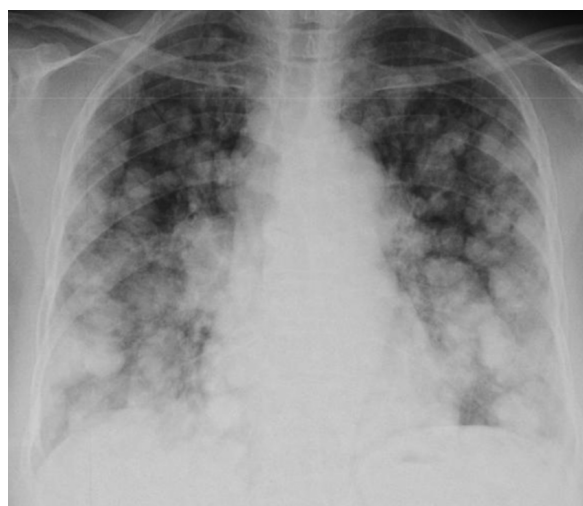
67-year-old woman with endometrial cancer. Chest radiograph shows innumerable pulmonary nodules with “cannonball” morphology.
